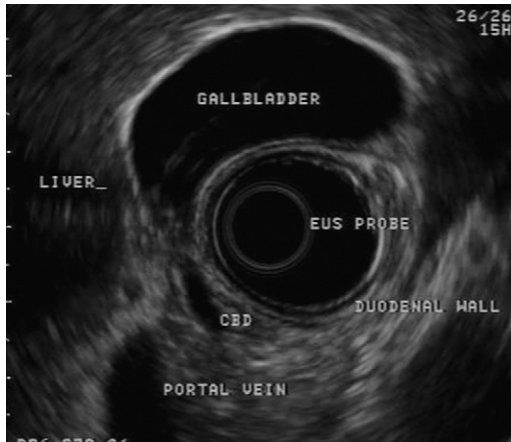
Endosonographic image obtained from the duodenal bulb showing the close proximity of the gallbladder and common bile duct to the duodenal wall.
